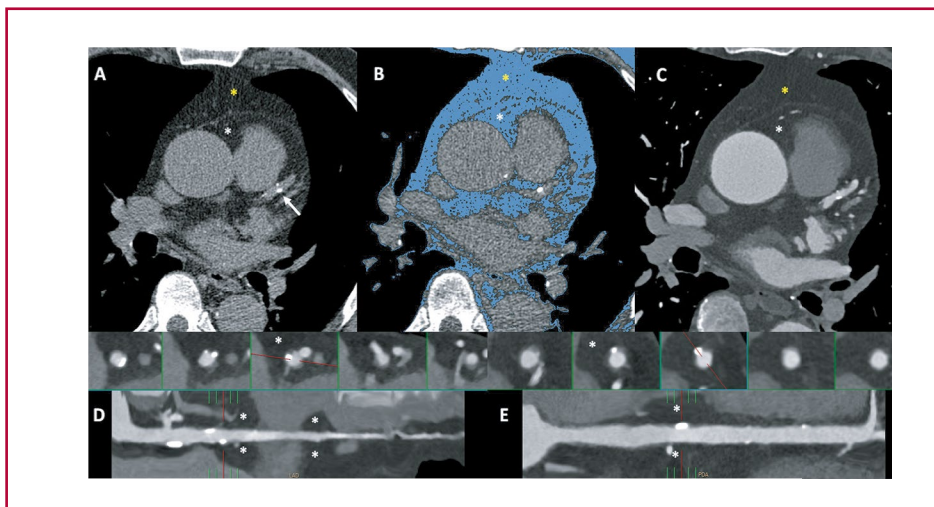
Calcium score (panels A and B) and CT coronary angiography (panels C-E) in a hypertensive 72-year old male patients with atypical chest pain. Both the unenhanced study (calcium score) as the coronary angiography allow the discrimination between epicardial fat (white asterisk) and paracardiac fat (yellow asterisk), as well the calculation of their volume and density. Multiplane reconstructions of the anterior descending (panel D) and right coronary (panel E) arteries are used to assess perivascular fat (asterisk).
